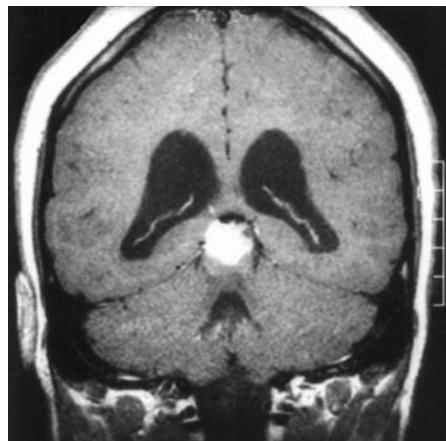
On T1-weighted MRI, pineoblastoma shows homogeneous contrast enhancement.
